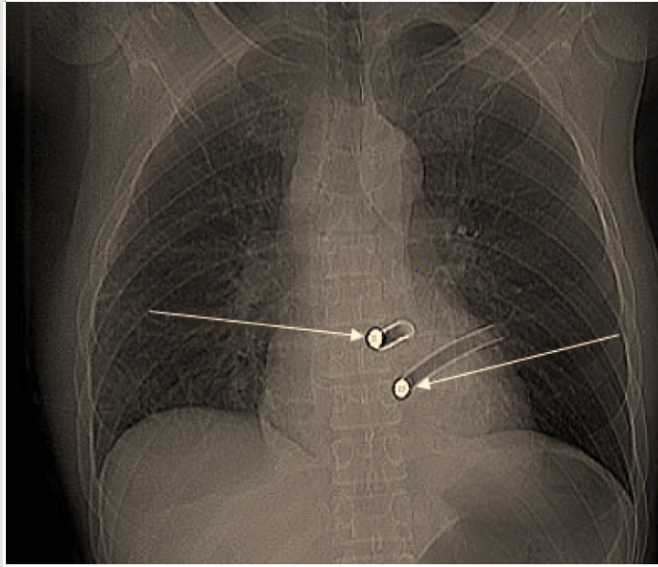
Plain panoramic frontal chest X-ray, foreign bodies (arrows) are marked.
